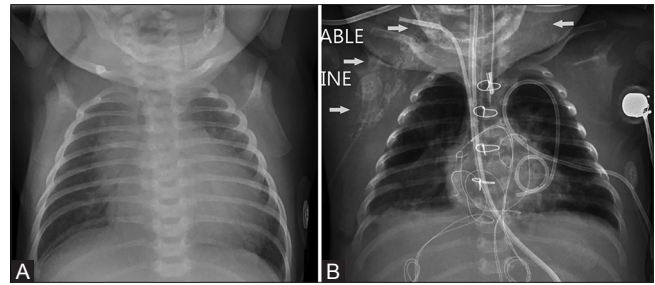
(A and B): Ex full term infant with hypoplastic left heart syndrome who was on bypass during surgical repair followed by ECMO for low cardiac output shortly after surgery. The patient was deceased at the time this study was conducted. Chest radiograph at 8 days of life (A) notable for absence of soft tissue calcifications and at 7 weeks old (B) with marked asymmetric right greater than left axillary, periscapular, and peri-clavicular calcifications as indicated by white arrows
